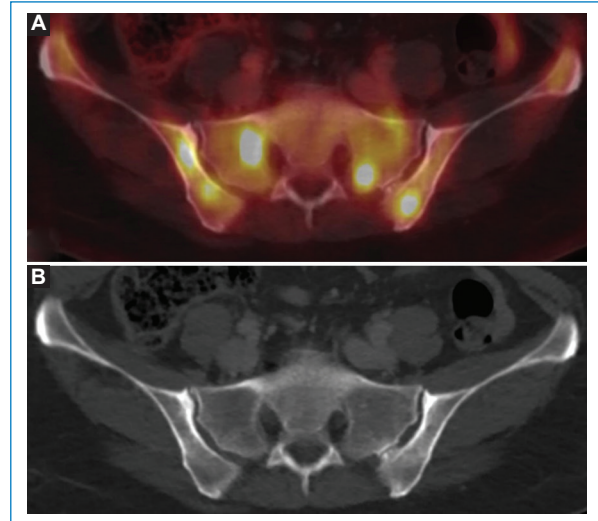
Axial FDG PET/CT fusion showing multiple hypermetabolic foci in the bone marrow of the pelvic bones (A) without representation on axial CT of the pelvis (B), compatible with multiple myeloma involvement.
